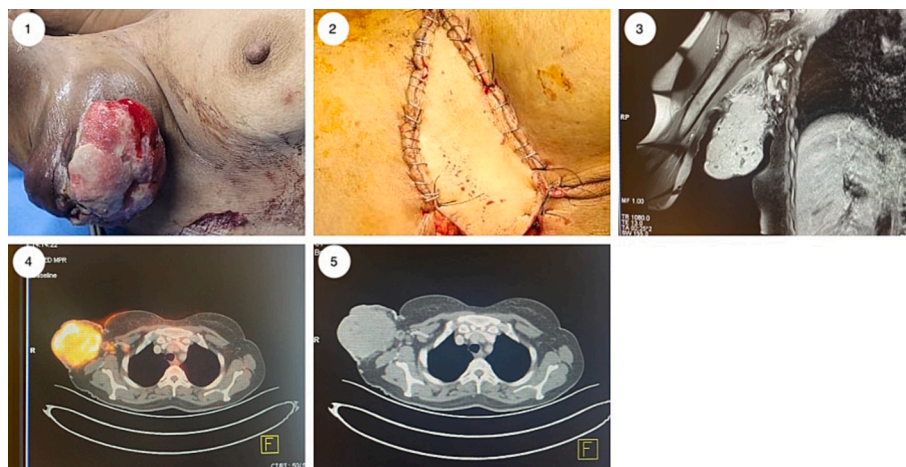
1. Preoperative image of right axillary mass; 2. Intraoperative image showing pedicled Latissimus dorsi flap reconstruction; 3. MR image showing a well-defined lobulated lesion in the right axillary recess with locoregional lymphadenopathy; 4. PET scan showing a large metabolically active heterogeneously enhancing soft tissue mass likely involving the axillary tail of the right breast with multiple right axillary and subpectoral lymph nodes; 5. CECT scan showed a soft tissue mass likely involving the axillary tail of the right breast.
